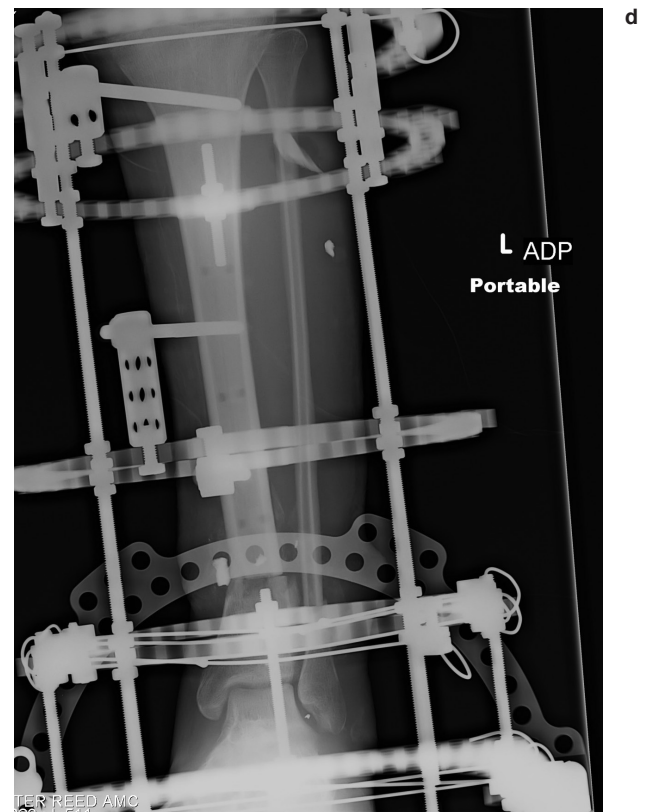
Clinical photograph (a) and radiograph (b) at presentation of a patient with a segmental distal tibial defect, near circumferential soft tissue injury, and contralateral transtibial amputation. Acute shortening was performed to facilitate wound closure and opposition of the bone ends (c, d).
